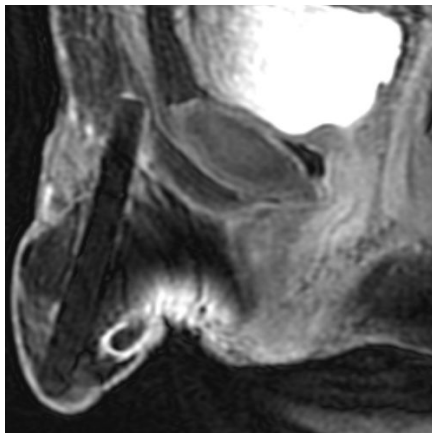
Contrast-enhanced sagittal T1-weighted image of urethrocutaneous fistula after sex-transformation surgery.
